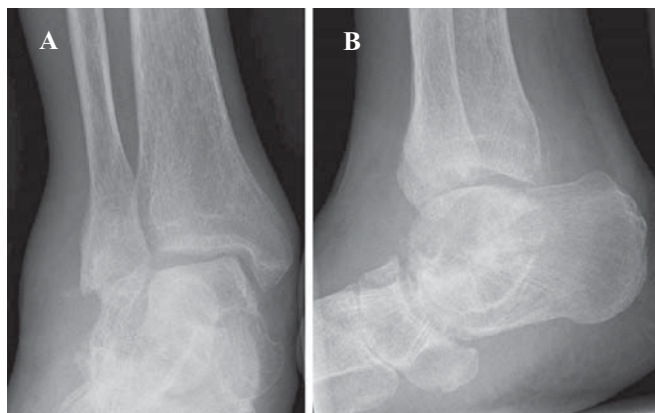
Radiograph of the patient's right ankle. Talotibial joint space shows spread and severe subtalar joint destruction caused by rheumatoid arthritis
